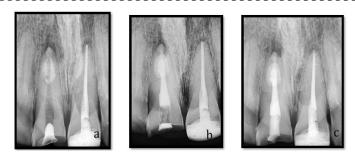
(a) MTA plugging at apical third of the root; (b) obturation by backfill; (c) Post endodontic restoration The patient was then recalled after one week, at one month, three month and six-month interval for periodic follow-up. There is gradual decrease in periapical lesion evident in radiograph (Fig.8)
